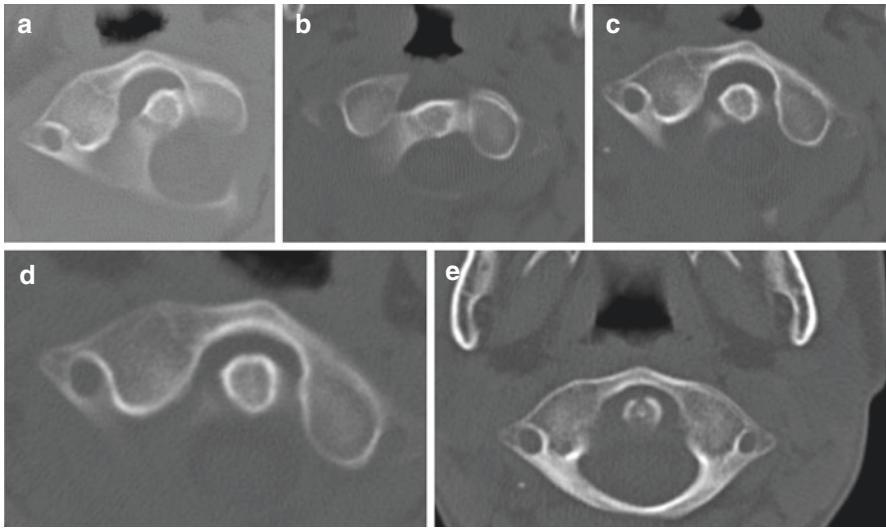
Gradual correction (CT scan; transverse section; (a–e))
